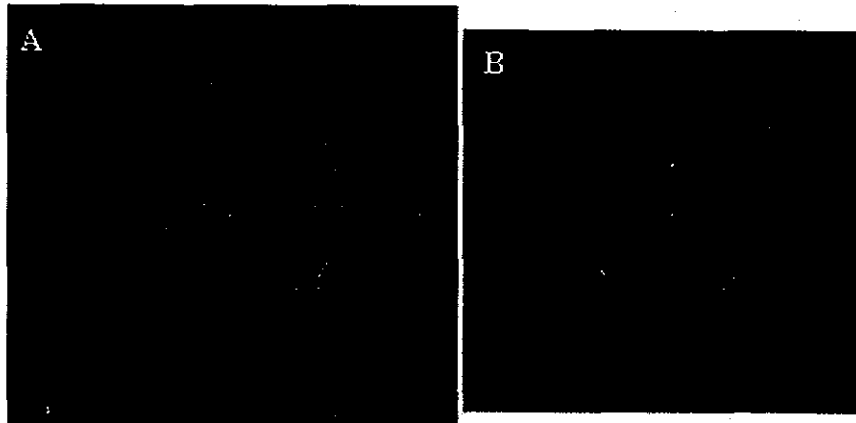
Images of a coronary artery at the same cross-section obtained with two intravascular ultrasound systems. A: Atlantis. B: Intrafocus. There were no significant differences in representing the plaque characteristics. The measured values from the two systems were as follows. Atlantis: MLD, 2.6 mm; LA, 7.4 mm²; VD, 5.2 mm; VA, 23.5 mm². Intrafocus: MLD, 2.5 mm; LA, 6.3 mm²; VD, 4.8 mm; VA, 20.7 mm². All parameters from Atlantis were larger than those from Intrafocus.
